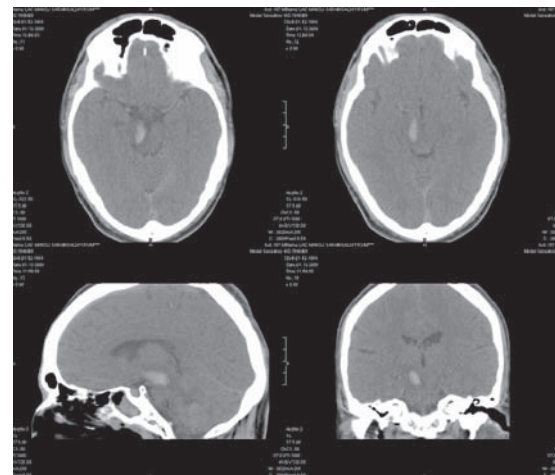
CT images showing the location of bleed
